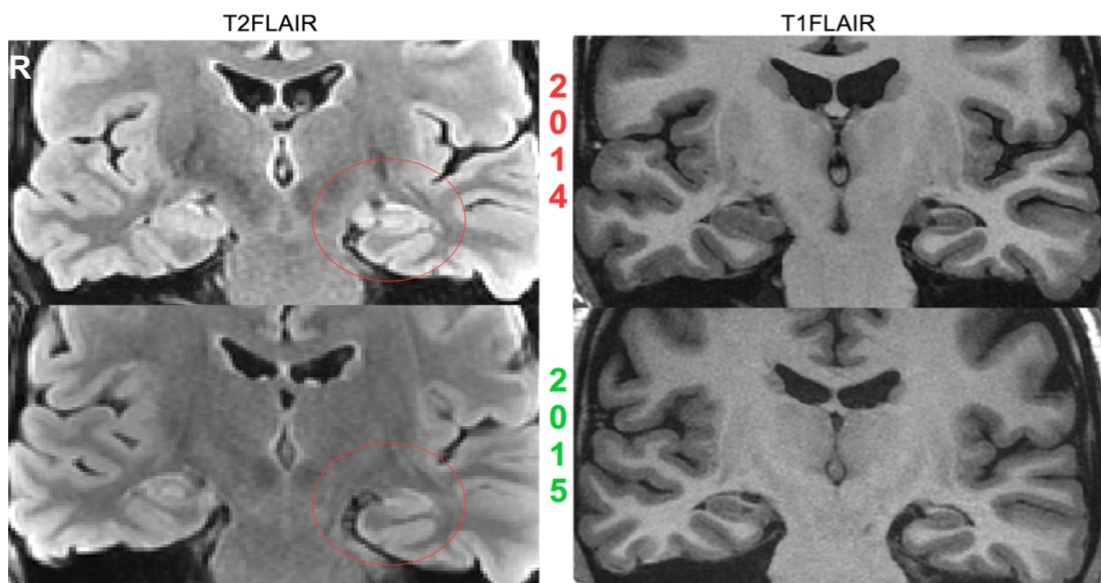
Patient 38: left HS. Despite signal hyperintensity on T2FLAIR and volume loss on T1FLAIR, HS was only diagnosed in 2015. Lesion conspicuity was similar for both MRI sessions. R = right.
